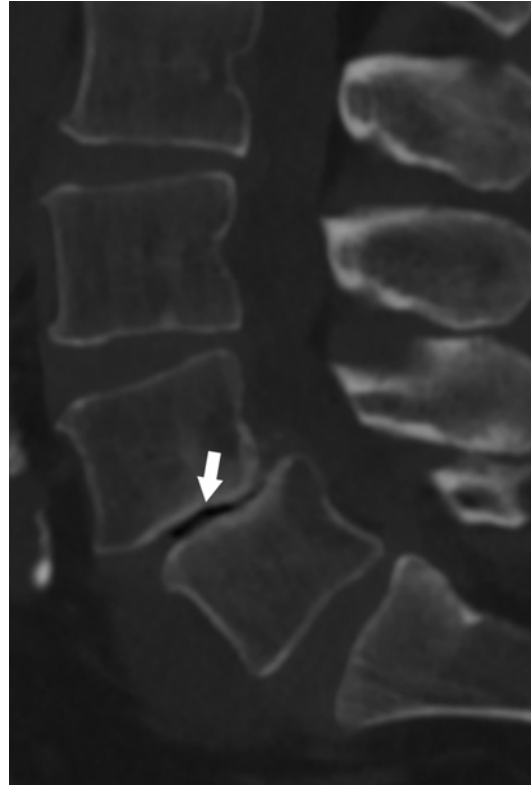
Spondylolisthesis. Sagittal CT reformat shows L4/L5 degenerative spondylolisthesis with major disk space narrowing and intradiscal gas (*arrow*)
